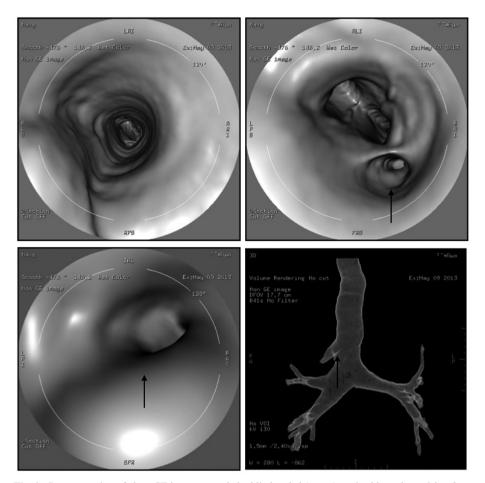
Reconstruction of chest CT images revealed a blind-ended (arrow) tracheal bronchus arising from the right side with an aberrant RUL.
